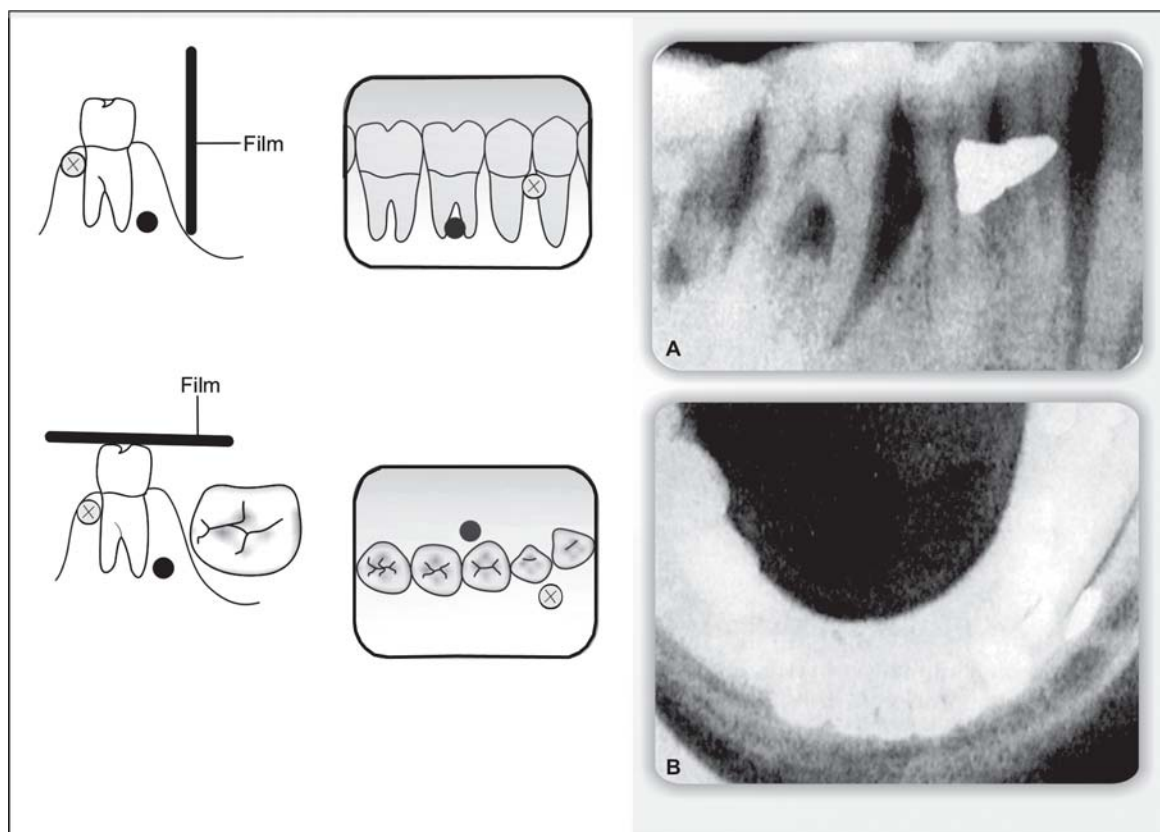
Right angled localization technique. Two films are exposed at right angles to each other to identify the location of an object. The periapical radiograph (A) will demonstrate the superior inferior and anterior-posterior position of the objects. A cross-sectional occlusal radiograph (B) will demonstrate the anteroposterior and buccal lingual positions. Thus these two radiographs will demonstrate all three dimensions of an area, and the location of objects can be identified
